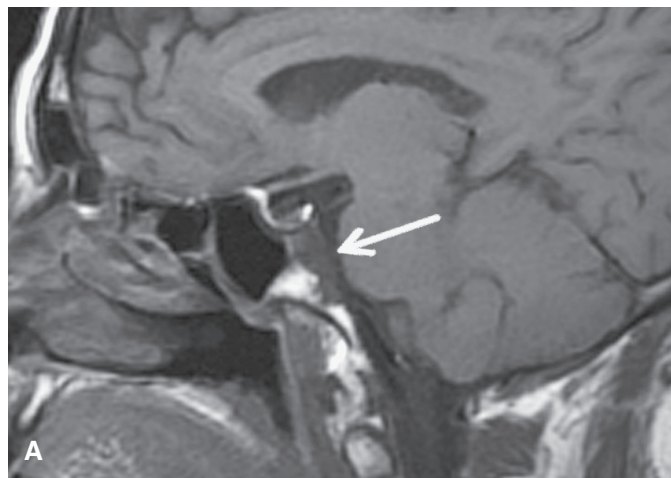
A 60-year-old woman with small early-stage clival chordoma. *A:* Sagittal, T1-weighted MR image shows irregular low-signal mass (arrow) in posterior superior clivus. *B:* Axial, T2-weighted MR image shows a high T2-signal mass (white arrow) with minimal extension into prepontine cistern but no mass effect on the basilar artery (black arrow) or other vessels.
